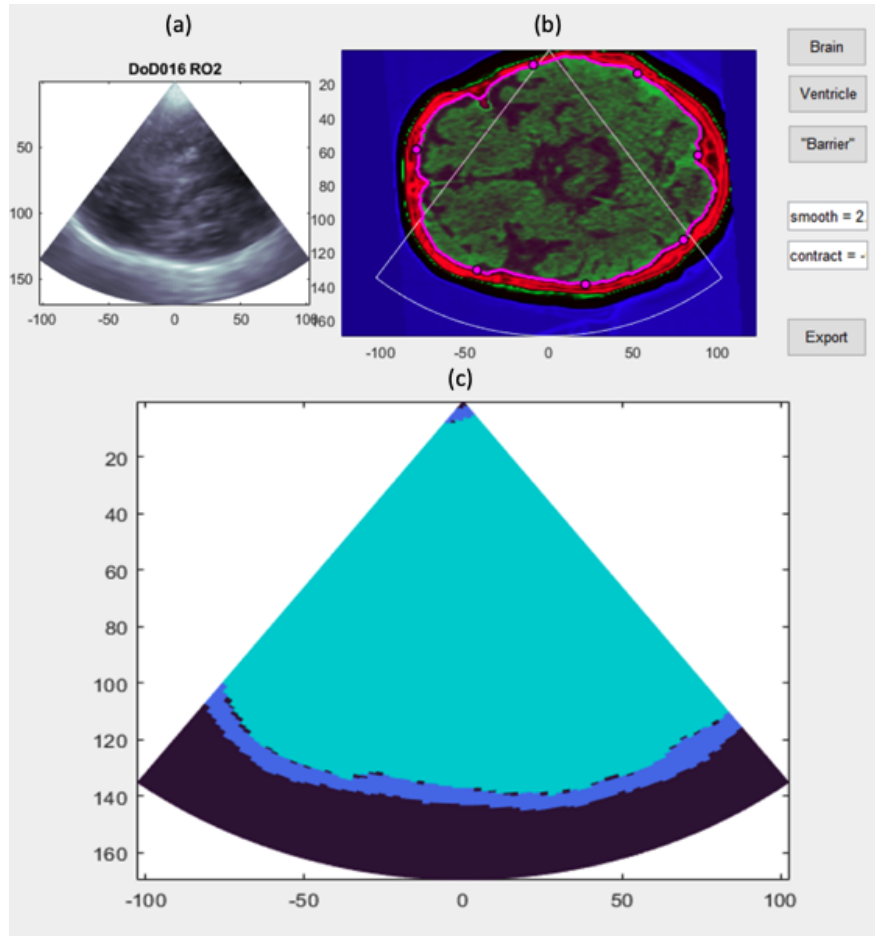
CT brain mask constructed by registration with B-Mode ultrasound for patient # 16 at the right oblique plane. (a) B-mode ultrasound data. (b) An overlay of the ultrasound plane on the CT image. (c) Resulting brain mask (cyan) and skull mask (blue).
